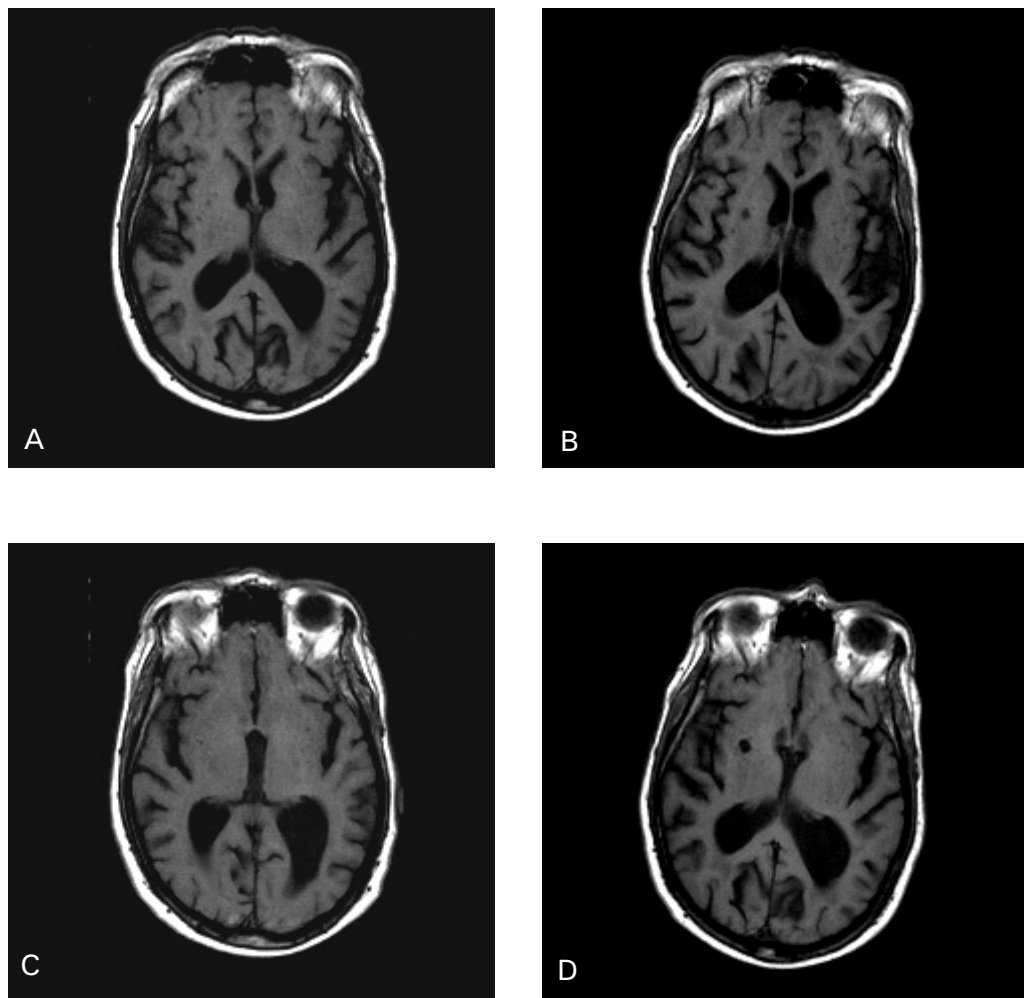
Incident lacunar infarct. A,C: T1-weighted spin echo MR image at baseline. B,D: T1-weighted spin echo MR image at follow-up with hypointense lesion in right putamen.
